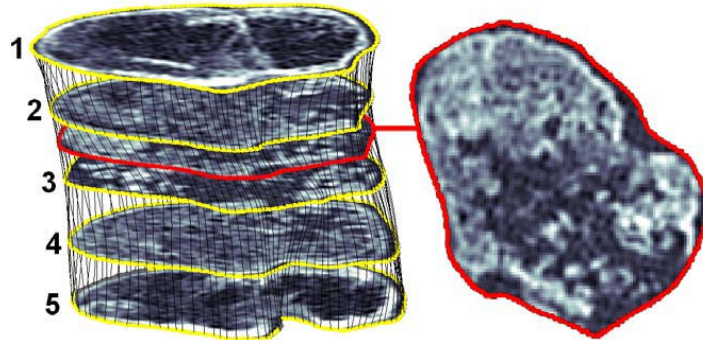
ROIs are defined by the user in 5 CT scans (yellow). The ROIs are divided into an equal set of points which are used to link them together. The interconnecting lines (black) are used to automatically generate ROIs in all CT images of the bone regenerate. An automatically generated ROI is seen in red.
